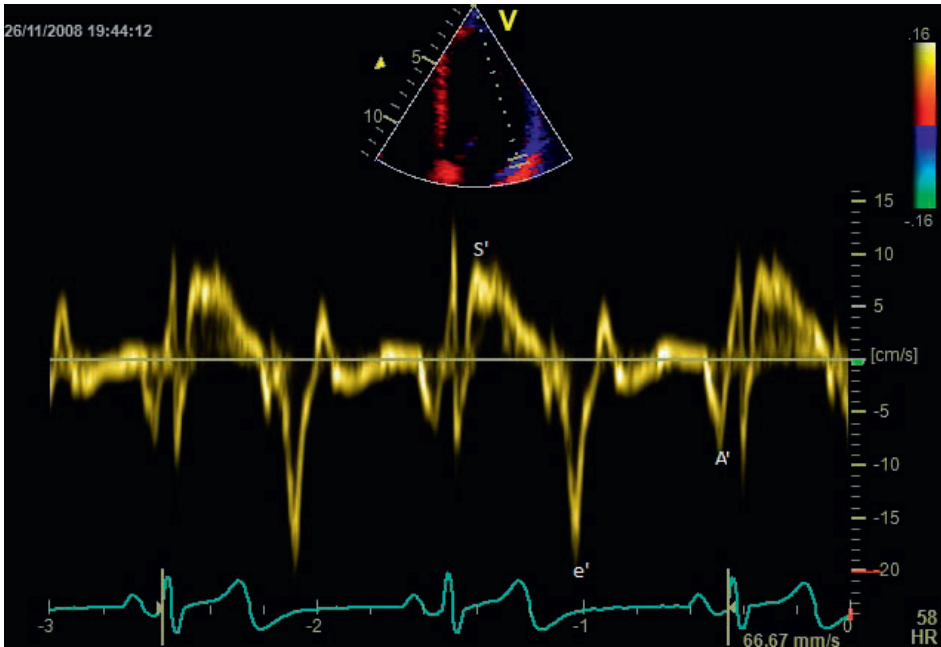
Tissue Doppler imaging of a normal heart. Four chamber view with the sample size in the lateral corner.
